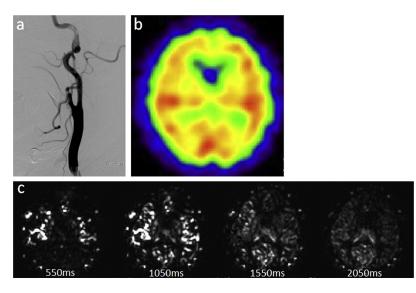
Postoperative imaging. (A) Left common carotid angiogram revealed marked revascularization of the left internal carotid artery (ICA) without any residual stenosis. (B) The brain single-photon emission computed tomography (SPECT) at rest demonstrated no significant laterality of cerebral blood flow (CBF). (C) Multiphase arterial spin labeling (ASL) images demonstrated improved perfusion in the left hemisphere and no difference between hemispheres.
